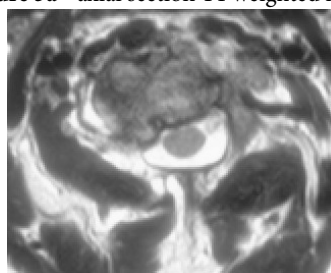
axial T2 weighted image Axial section Magnetic resonance imaging of Craniovertebral junction
